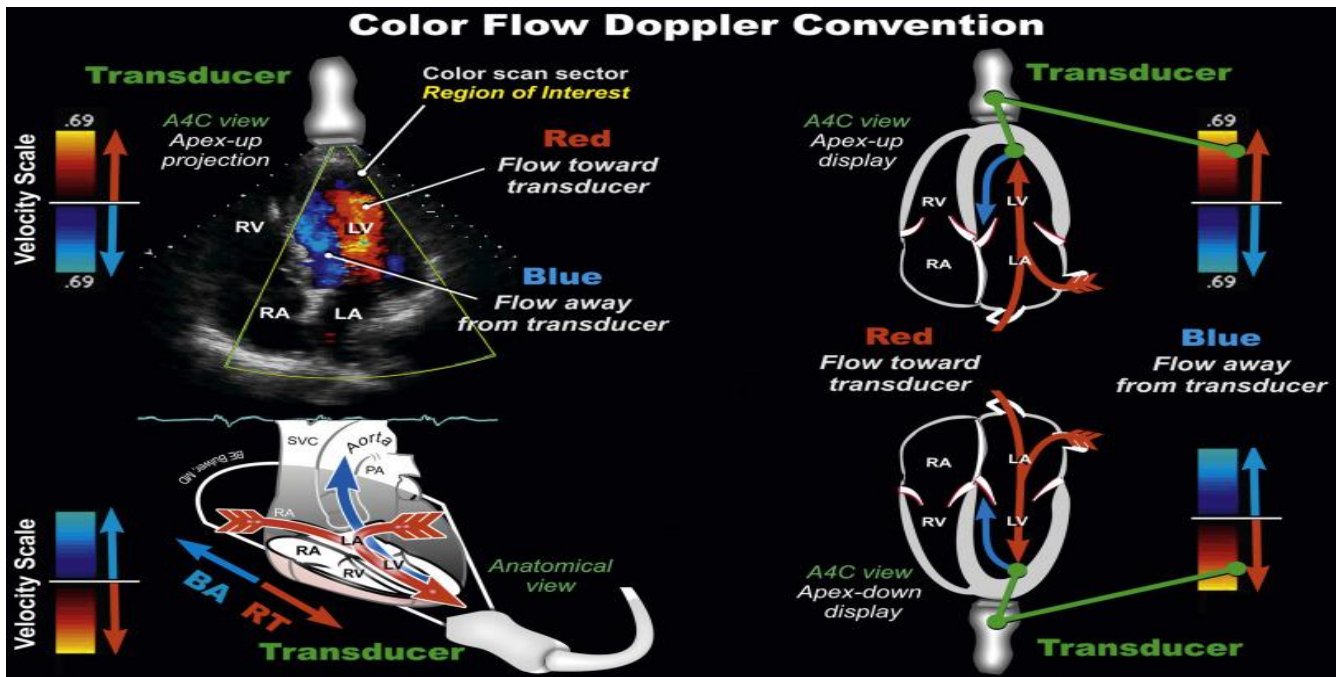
Color Doppler Flow Convention
